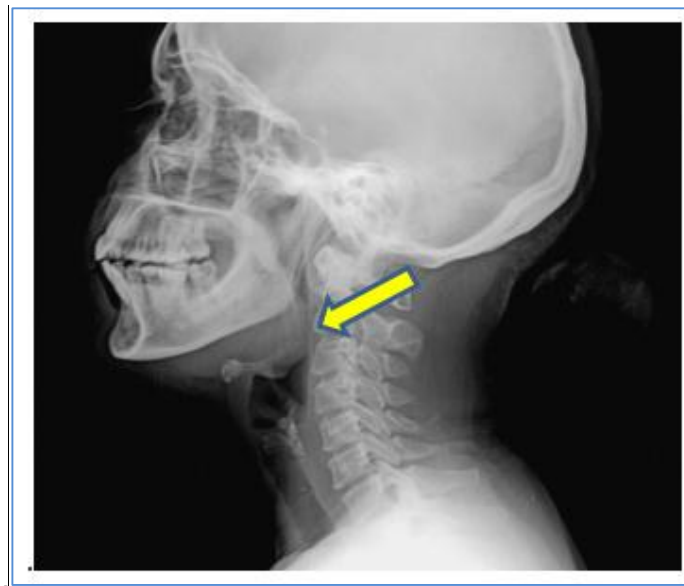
Lateral radiograph of the neck showed well-defined soft tissue opacity obliterating the pharyngeal air column
